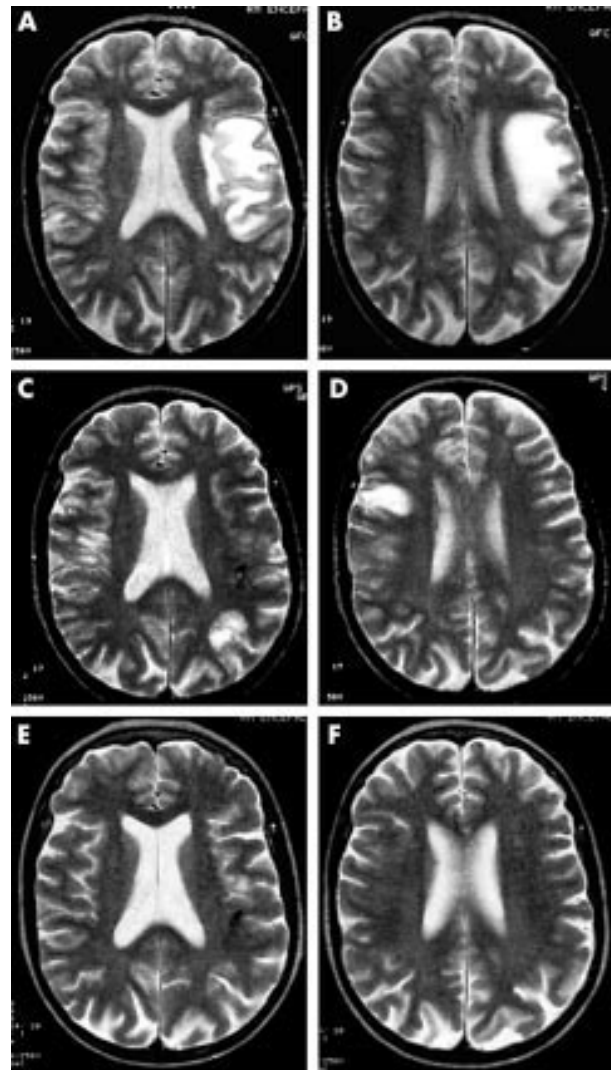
Axial T₂ weighed sequence MRI (0.5 T; TR (repetition time) 2500 ms; TE (echo time) 25 ms) at admission (A, B), after intravenous methylprednisolone and cyclophosphamide (C, D), and after anti-TNF therapy (E, F).
